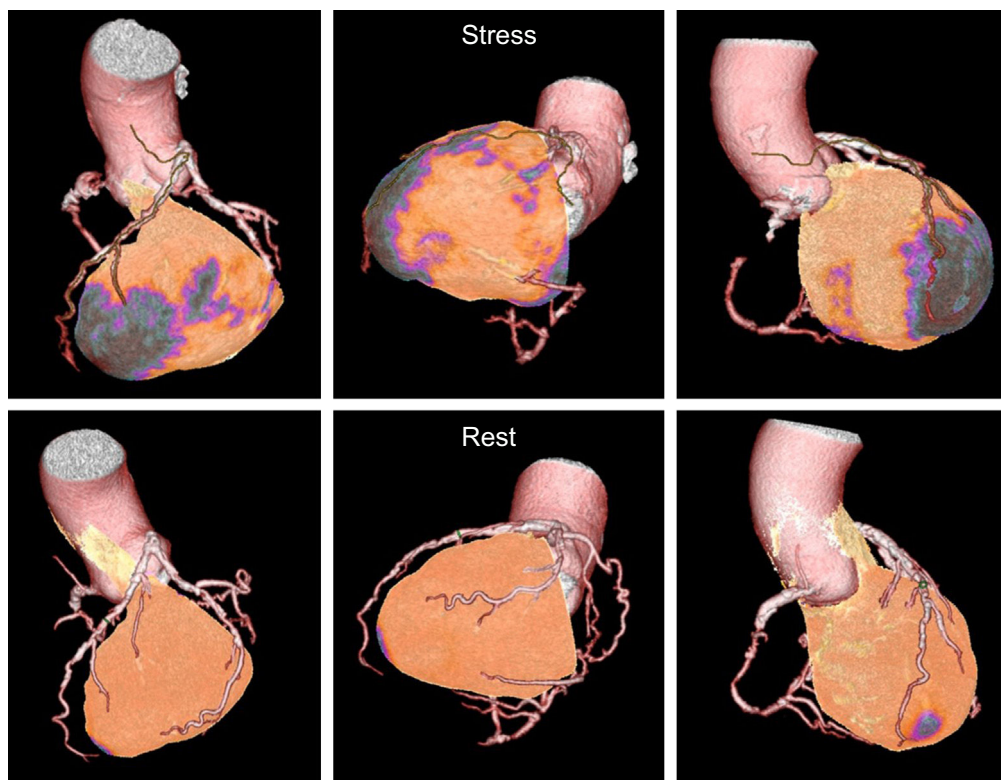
Stress-rest computed tomography showing diffuse coronary disease, predominantly in the left anterior descending artery and the right coronary artery, associated with a large antero-apical and inferior perfusion defect (above) with complete reversibility at rest (below).
